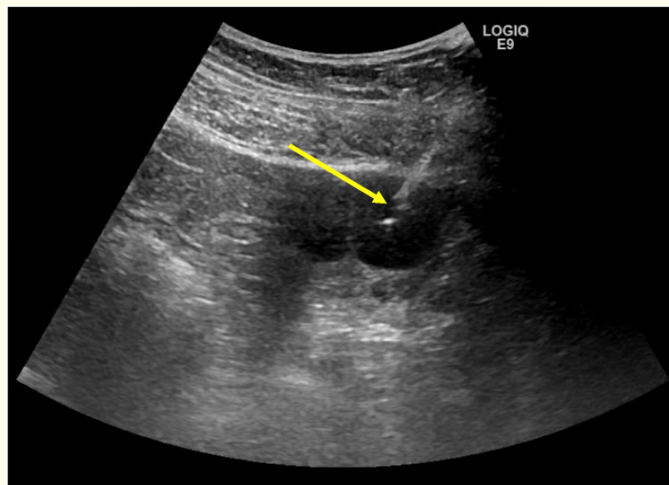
Courtesy ref no. 10-Transabdominal ultrasound-guided oocyte retrieval (arrow) in a patient with a BMI of 47.8 kg/m².
